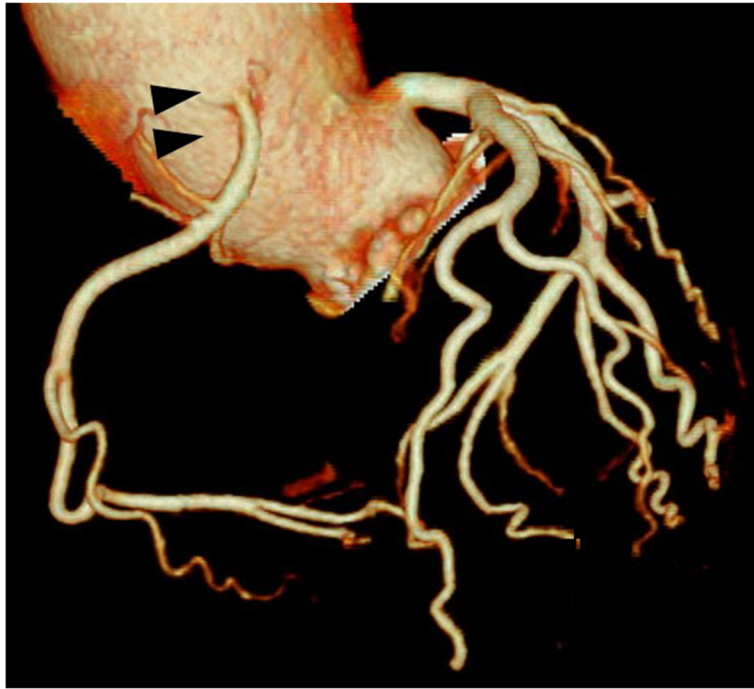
Preoperative evaluation of the coronary artery by computed tomography. The right coronary artery has high-take-off from the aorta and stenosis noted at its origin (arrows)
